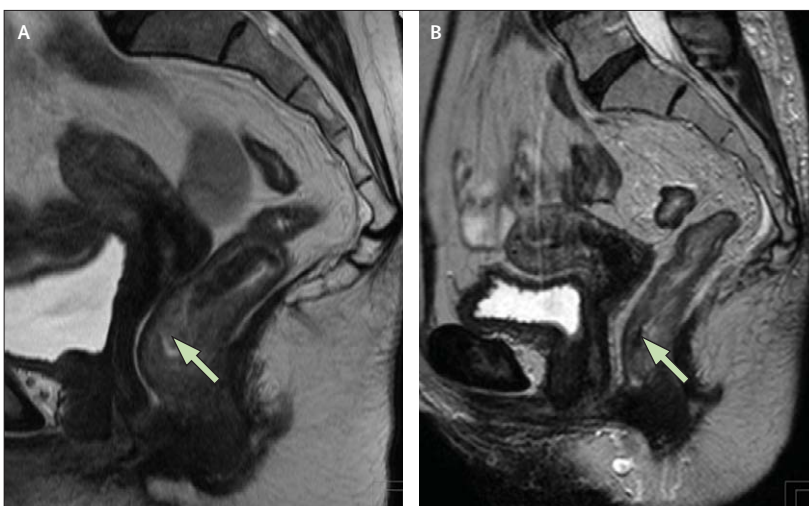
Sagittal T2-weighted MRI of T3 tumour
